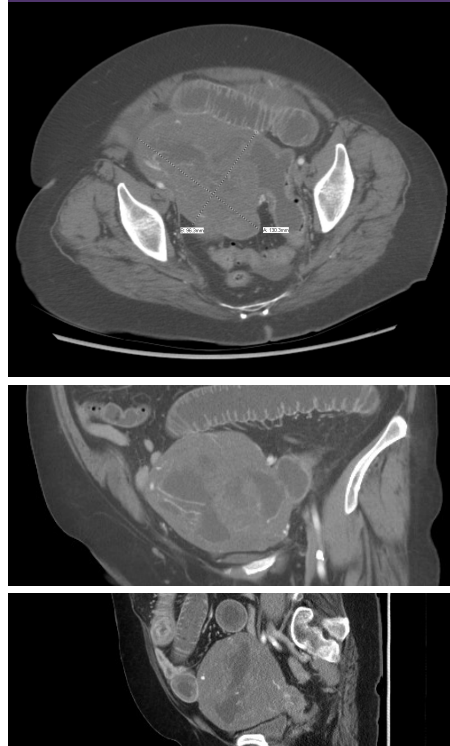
CT of Abdomen and Pelvis demonstrating large necrotic right pelvic mass (axial, coronal, sagittal images)
